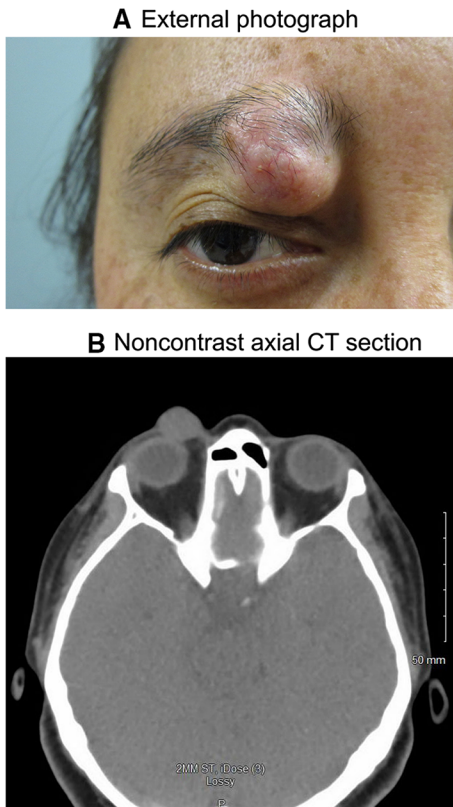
Clinical Presentation of Orbital Lesion and CT Imaging. a External photograph demonstrates right periorbital lesion. b Noncontrast axial CT imaging reveals mass occupying the right anterior orbit without involvement of the globe or postseptal extension
